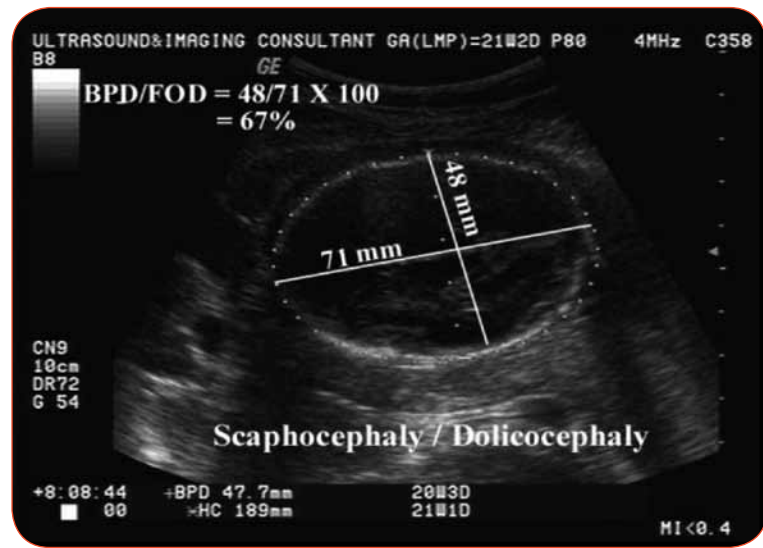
Sonogram of fetal head showing BPD and OFD measurement
